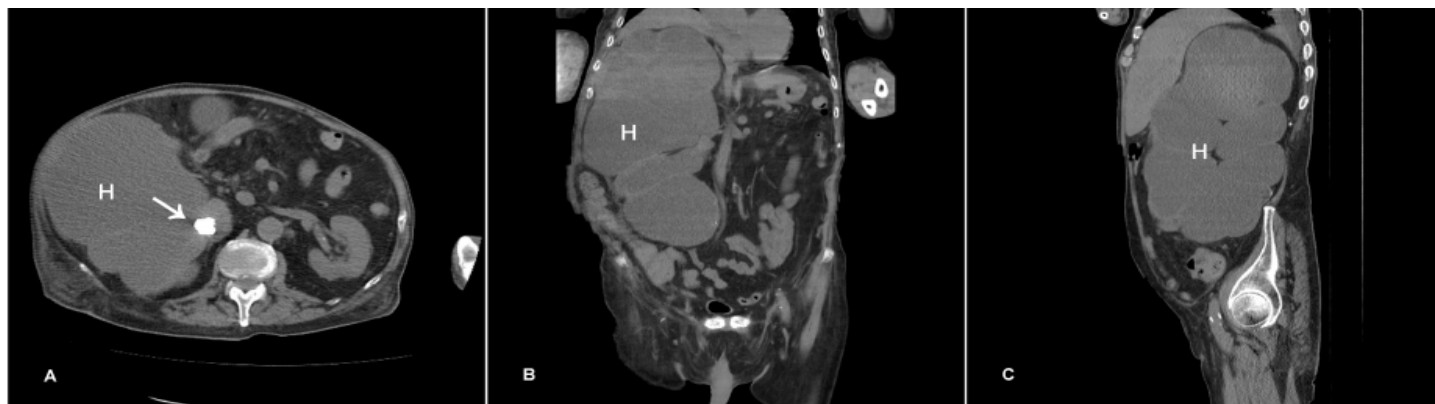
Computed tomography of abdomen showed right ureteral stone (white arrow) in a axial view (A), right giant hydronephrosis in a coronal (B) and sagittal (C) views. Abbreviation: H, hydronephrosis
